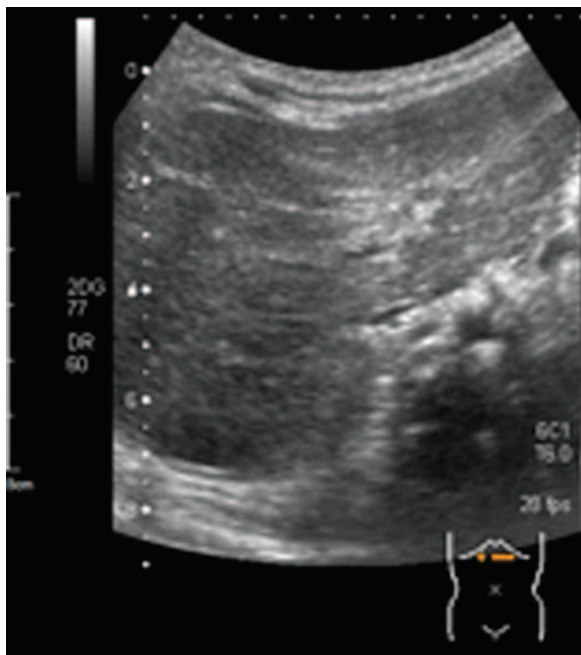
No lesions were detected under abdominal ultrasound after a 4.5-month treatment course of propranolol.
